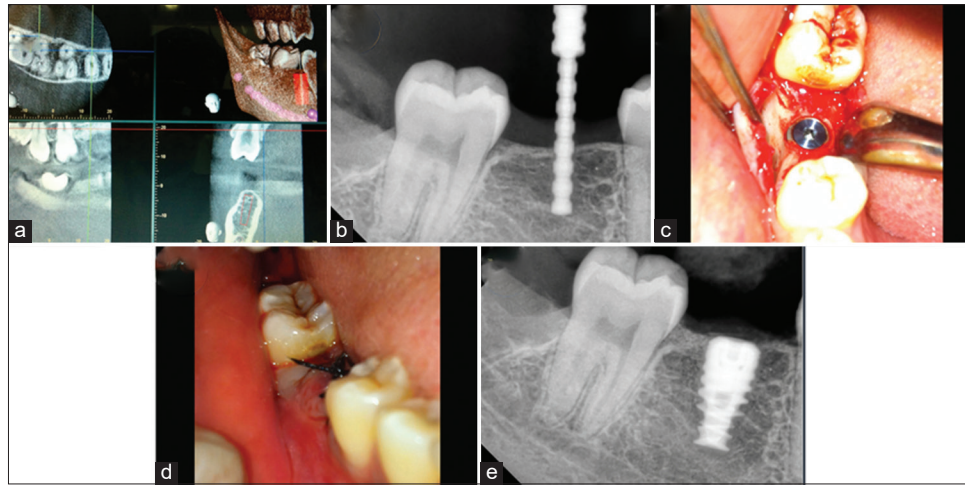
Initial implant placement procedure. (a) Pre-operative cone-beam computed tomography, (b) osteotomy angulation verification, (c) implant placement followed by cover screw placement, (d) suturing, (e) immediate post-operative intraoral periapical
